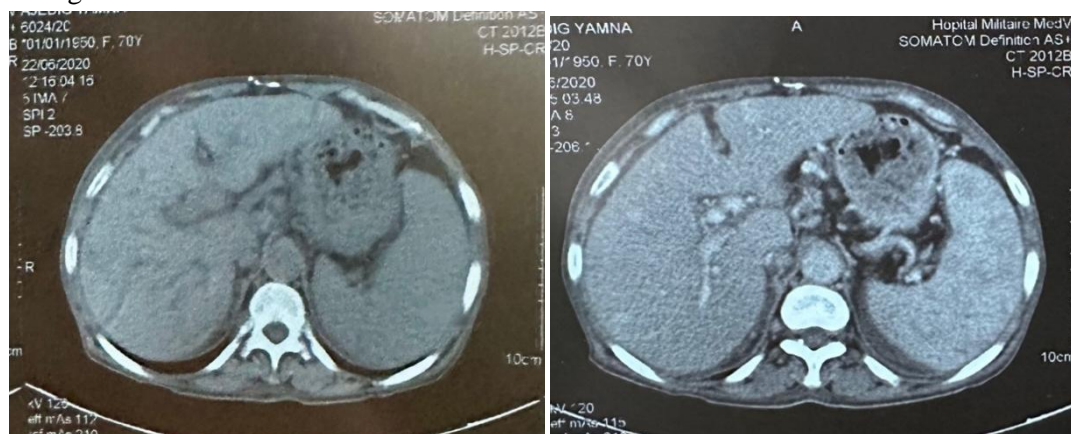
CT scan showing a duodenal lesional process (D2 and D3)
